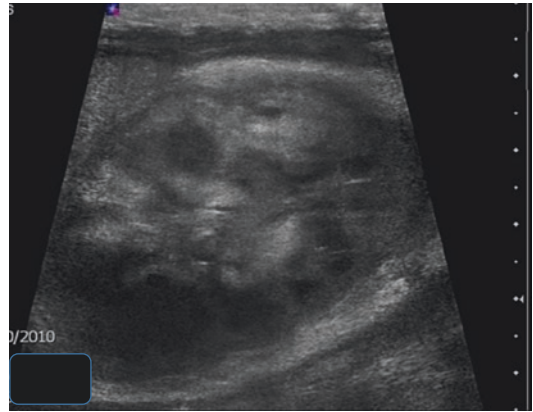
Renal vein thrombosis—Ultrasound. Sagittal scan through the right kidney—The kidney appears swollen. The kidney echogenicity is completely distorted alternating areas of hyper- and hypo-echogenicities
